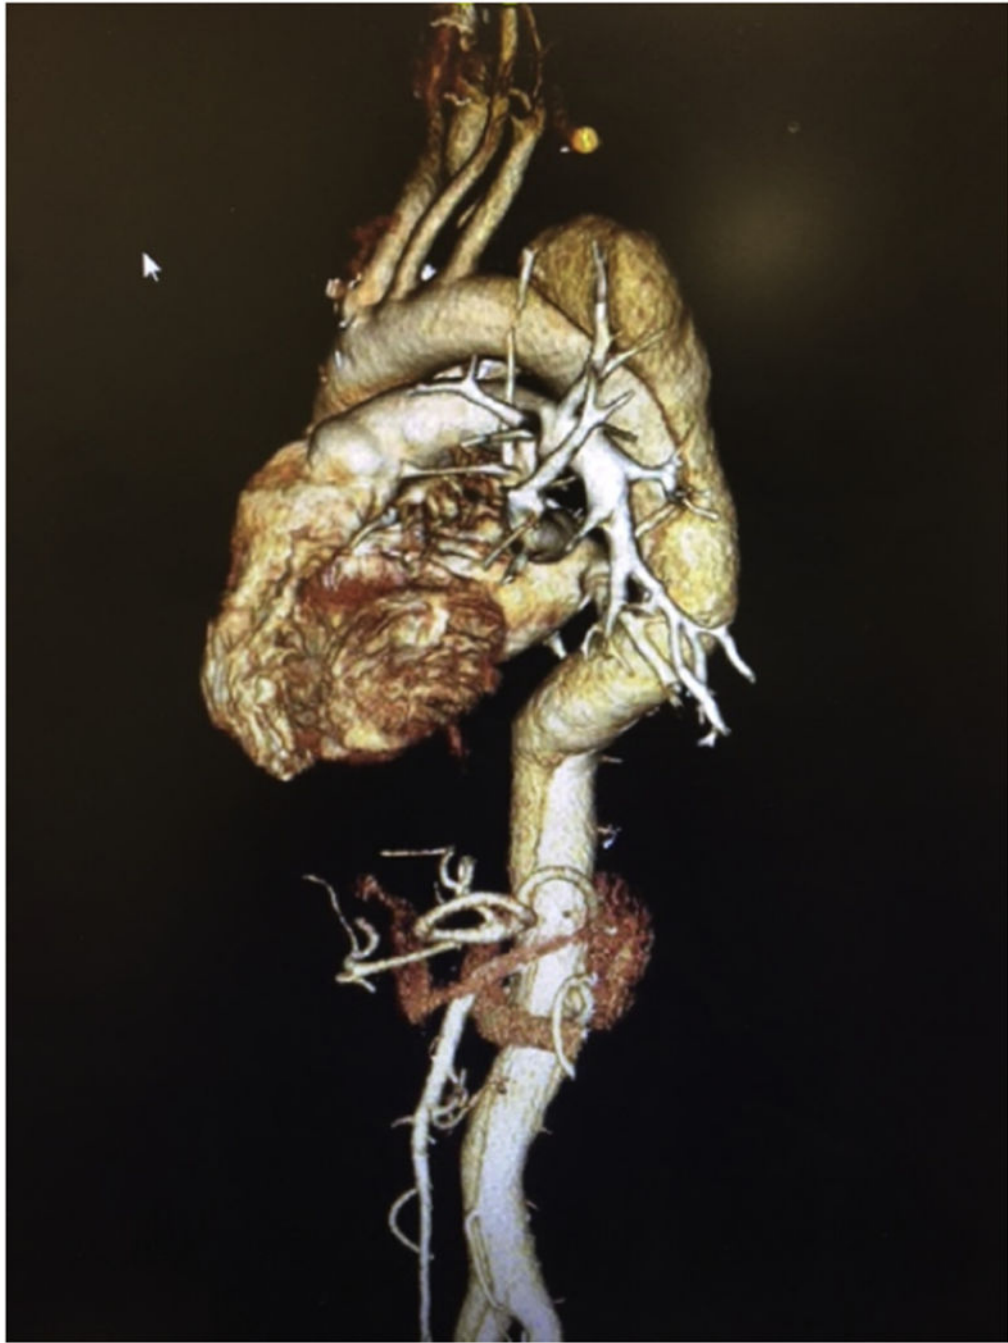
Contrast-enhanced computed tomography Tera- Recon Aquarius iNtuition three-dimensional reconstruction. Example of a false lumen originating from the greater curve of the proximal descending aorta and spiraling >180 degrees.
